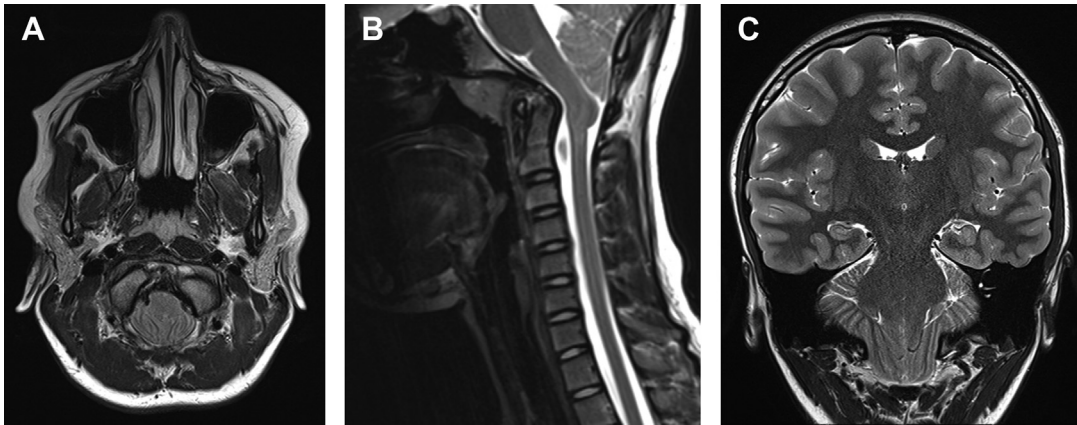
A 13-year-old girl with brief headaches and syncopal episodes due to Chiari I malformation. Axial, sagittal, and coronal T2-weighted MR images (A–C) show cerebellar tonsillar descent below the foramen magnum, with crowding of the adjacent CSF spaces and dorsal bump at the cervicomedullary junction. The patient underwent posterior fossa decompression.
